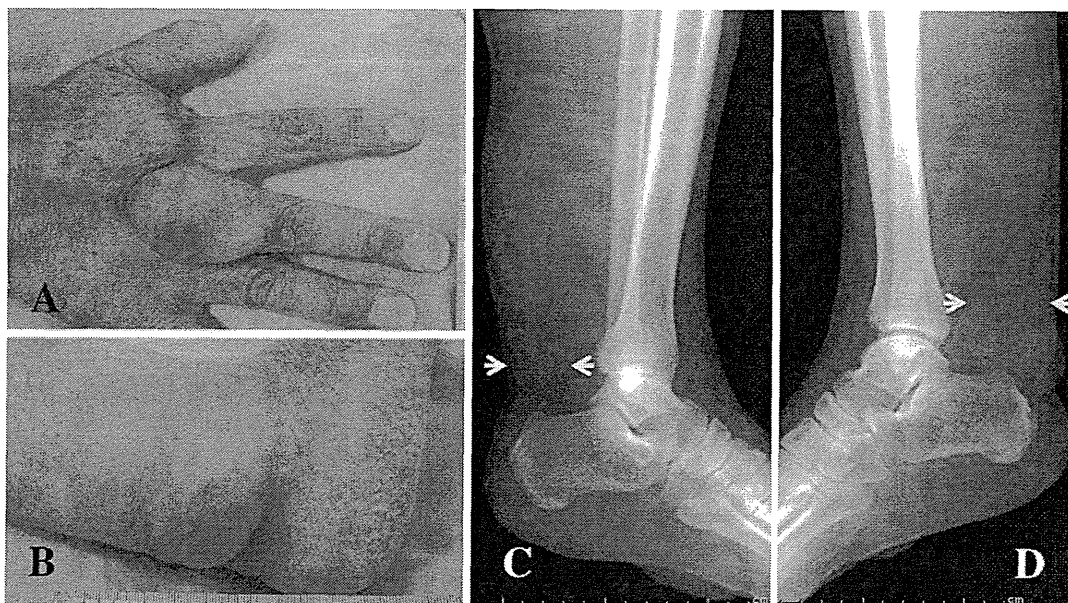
Large nodular tumors on the back side of the right hand (A) and the right Achilles tendon (B) are presented. Radiography of the Achilles tendons showed severe thickening of the bilateral Achilles tendons [left side (arrows in C): 30 mm, right side (arrows in D): 40 mm].
